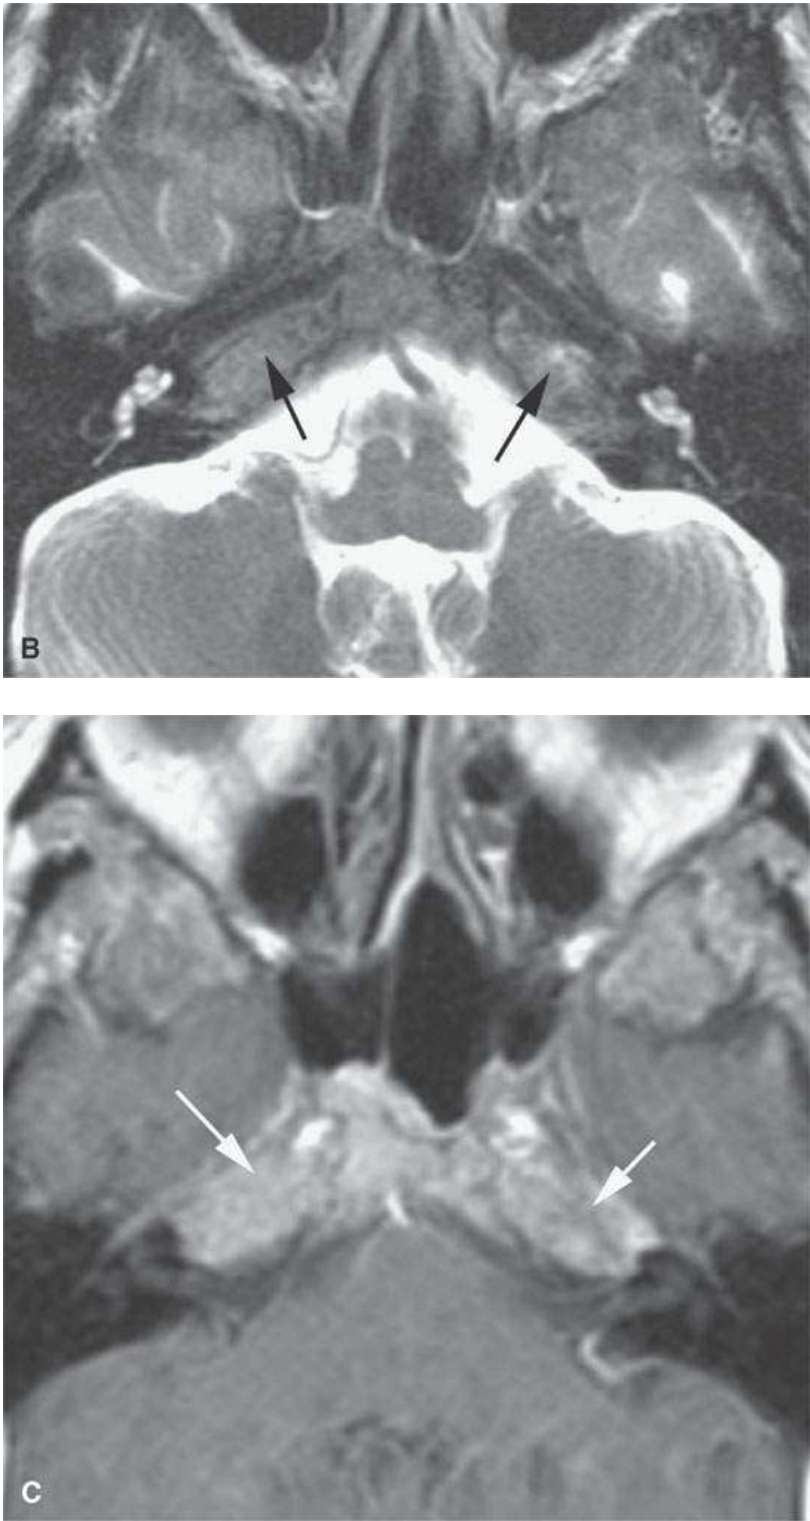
Contrast-enhanced magnetic resonance shows myeloma spreading freely in the marrow space of the skull base replacing its fat (*arrows*) content as seen on the T1-weighted noncontrast image (A) and T2-weighted image (B) this infiltration of the fatty marrow made essentially isointense to fat on the contrast-enhanced T1-weighted image in (cC).
